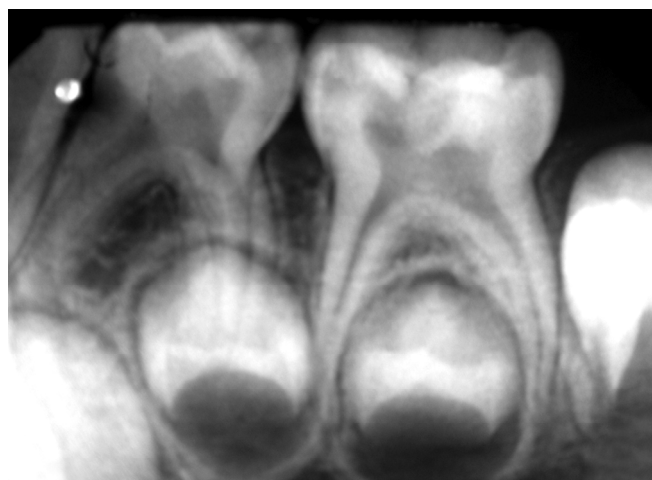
Preoperative radiograph of a deciduous mandibular second molar indicated for pulpectomy
